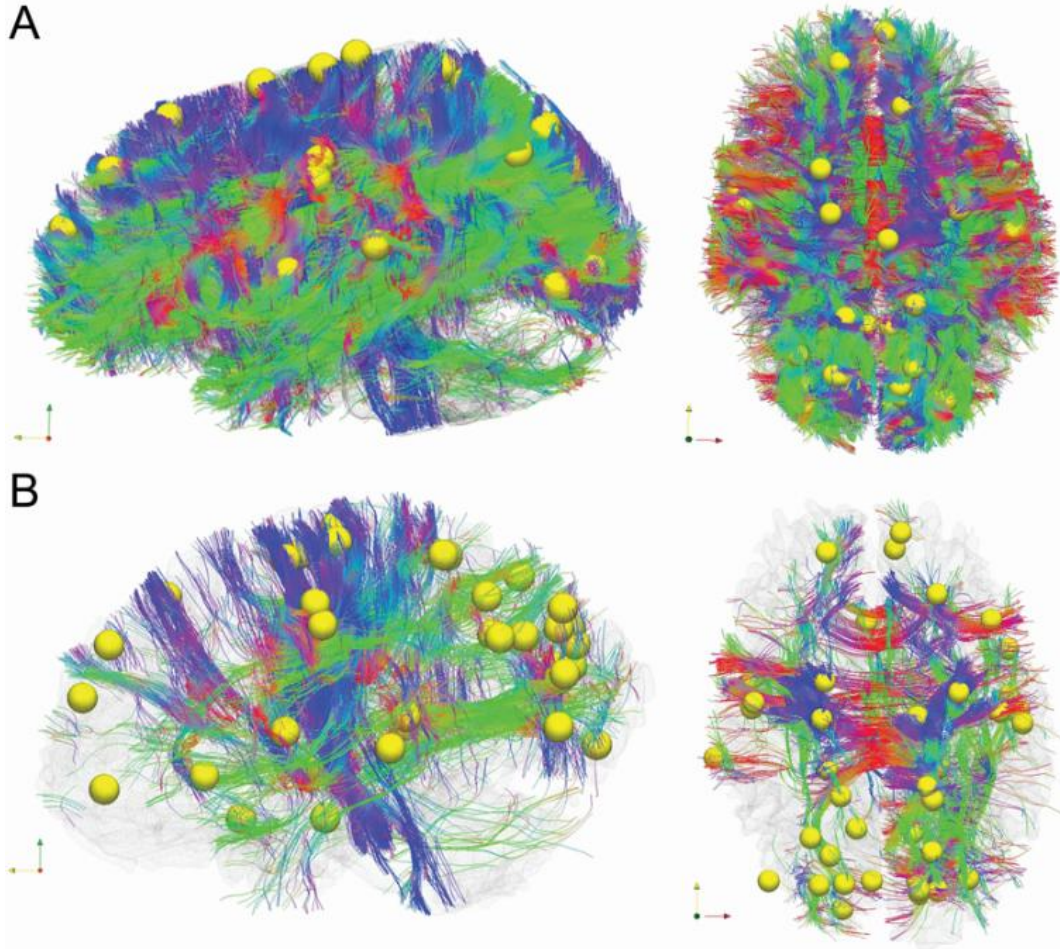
White matter fiber tractography of a randomly chosen control subject (A) and a randomly chosen mTBI patient (B) by using the 41 discrepant DICCCOLs (yellow spheres) as seed points. Despite the negative findings on the mTBI patient's structural MRI, the patient's white matter structure shows significant differences in the 41 discrepant networks in comparison with controls. Of particular note, the difference in the major white matter tracts between controls and patients is not because of the loss of white matter tracts in the patient; instead, it is the injury at these discrepant networks fail the fiber tractography algorithm when using the selected DICCCOL landmark as seed regions.
